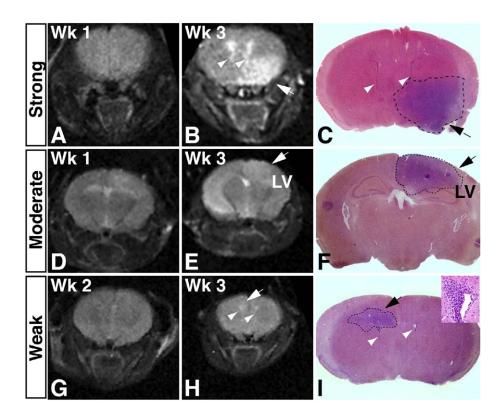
In vivo growth pattern of astrocytomas on the MRI scan
